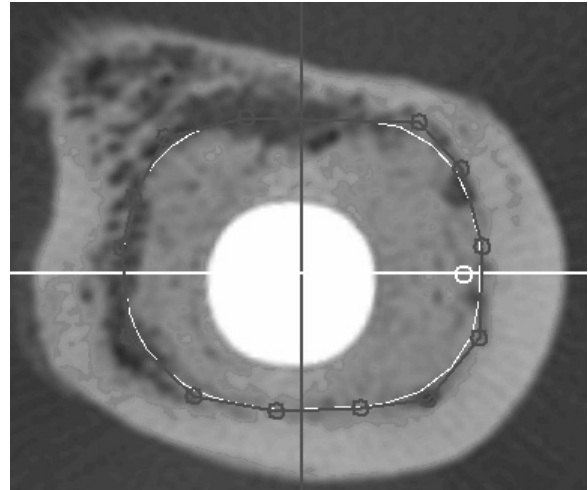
CT cross showing the desired (outer boundary) and system-generated (inner boundary) cut volume contour.
